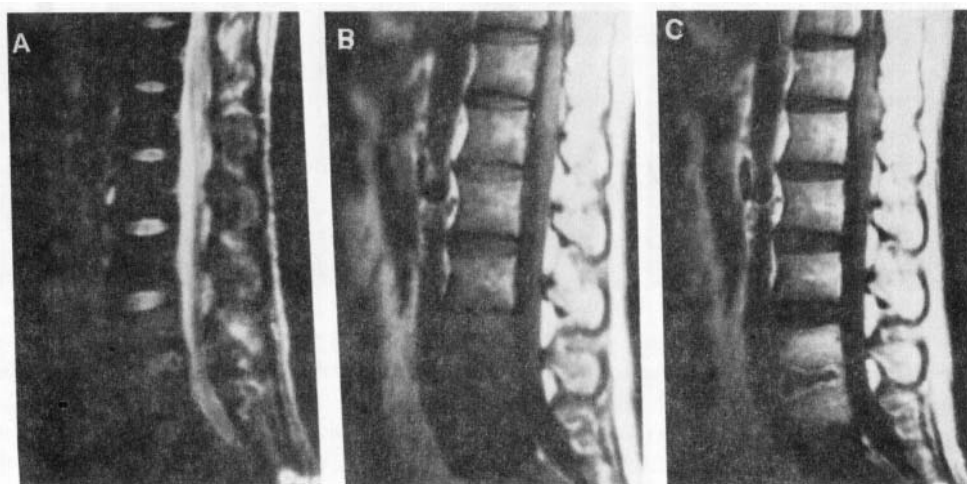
Pyogenic spondylitis. T2-weighted sagittal image (a) of lumbar spine shows evidence of mildly hyperintense L4 and L5 vertebrae with mildly swollen L4–L5 disk which shows heterogeneous signal intensity. T1-weighted image (b) shows hypointense L4 and L5 vertebrae. Postcontrast T1-weighted image (c) shows enhancing L4–L5 vertebrae with rim enhancement of the disk suggesting spondylitis with intervertebral disk abscess. Culture from the pus aspirated from the disk space yielded *Staphylococcus aureus*.
